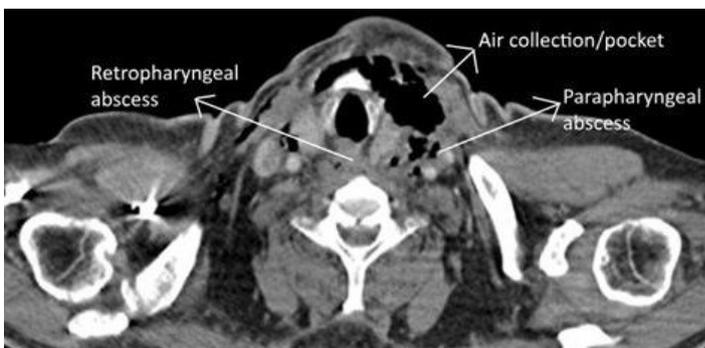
Annotated CT axial view of neck revealed presence of RPA, PPA and air pockets surrounding upper airway.
